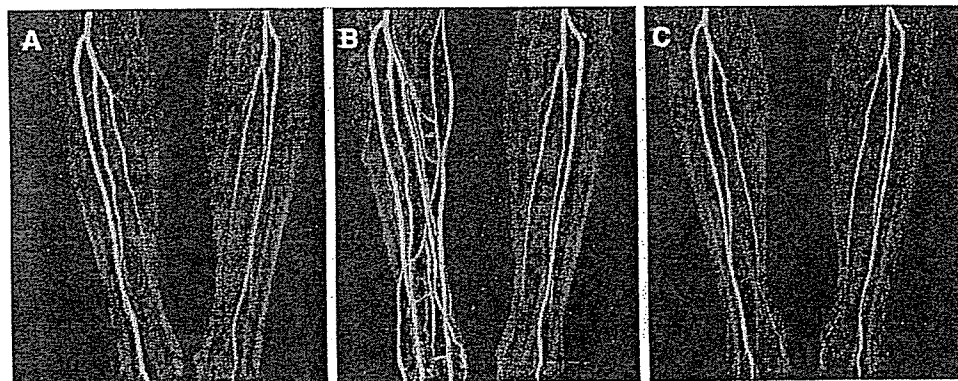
Computed tomographic angiography at (A) baseline, (B) 7 months, and (C) 1 year after cell transplantation. Early venous return of contrast material observed at 7 months spontaneously regressed by 1 year.
